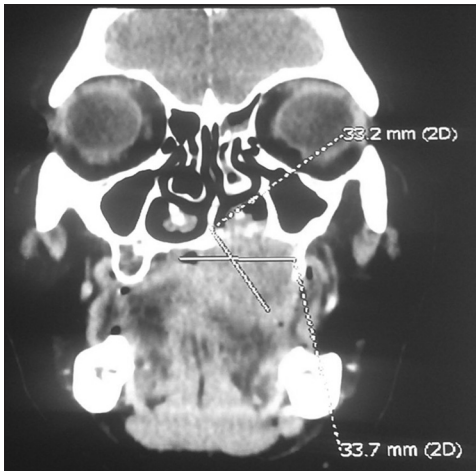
Cervico-facial CT showing the palatal tumor with bone lysis and extension to the ipsilateral nasal cavity
